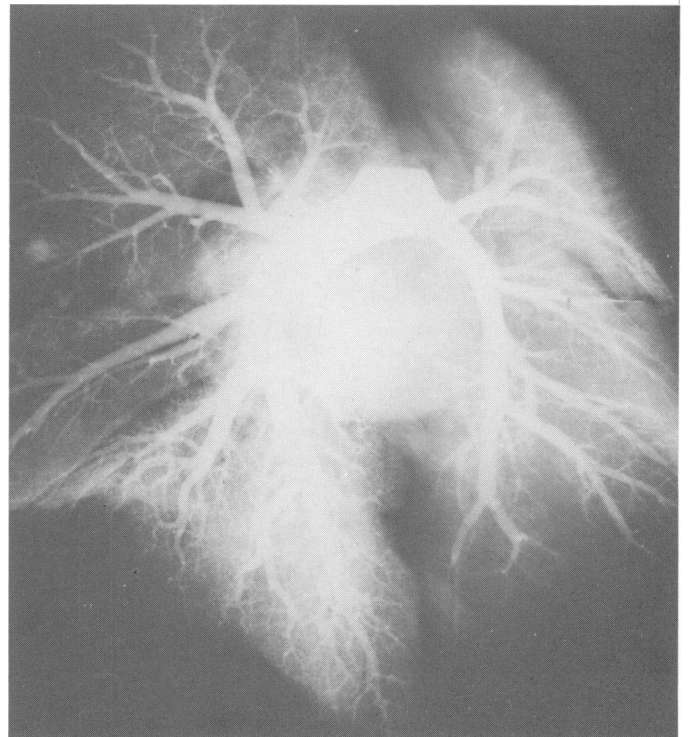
Radiograph of heart and lungs of M101. The left pulmonary arterial tree fills poorly due to vasculitis and thrombosis associated with necrotizing pneumonia.
